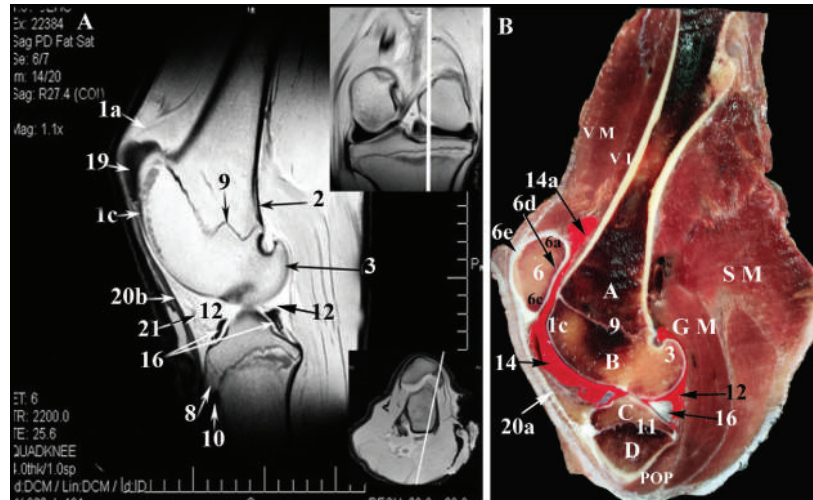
Sagittal MR image (A) and anatomic section (B) of the left buffalo stifle at the middle of the Fossa intercondylaris (dorsal is up and caudal is to the right of the viewer). Abbreviations as previous.
